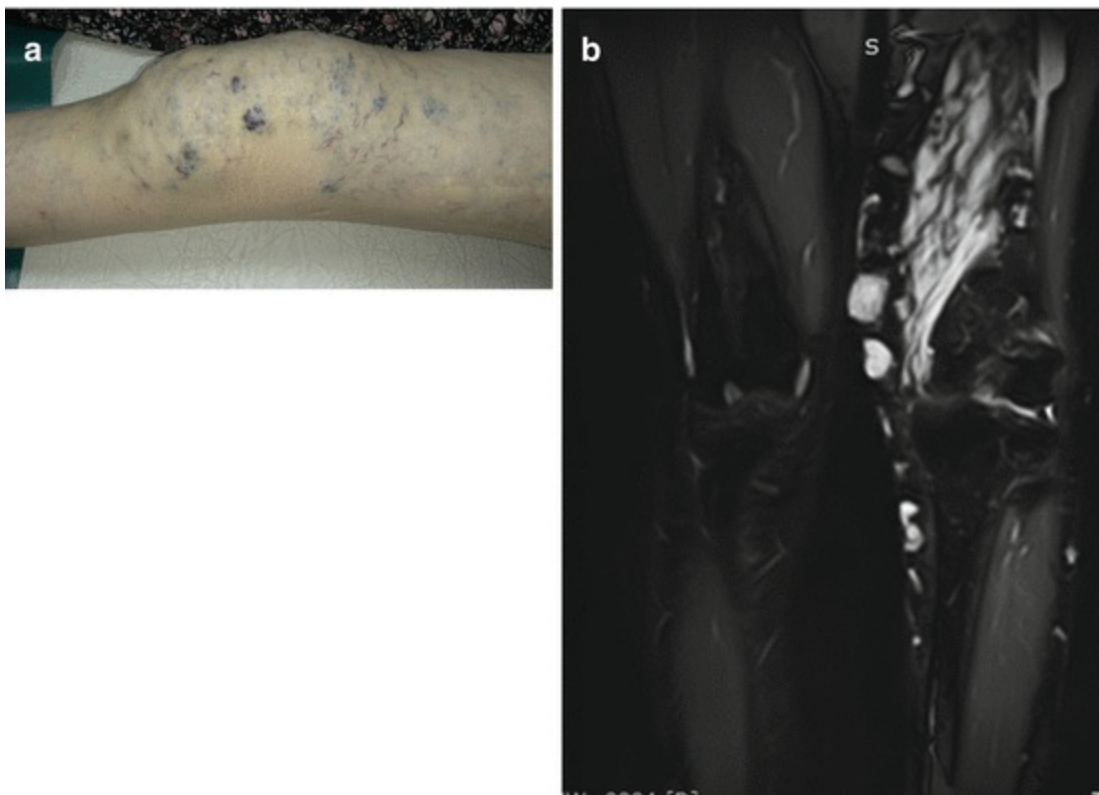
Diffuse venous malformation of the left lower extremity: (a) clinical view of the knee region; (b) magnetic resonance imaging
